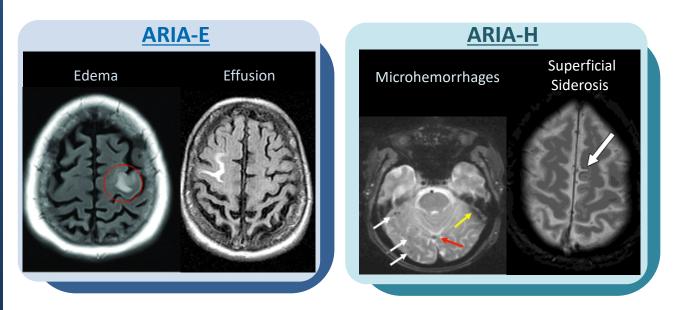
MRI Images of ARIA-E and ARIA-H¹⁰⁻¹²
